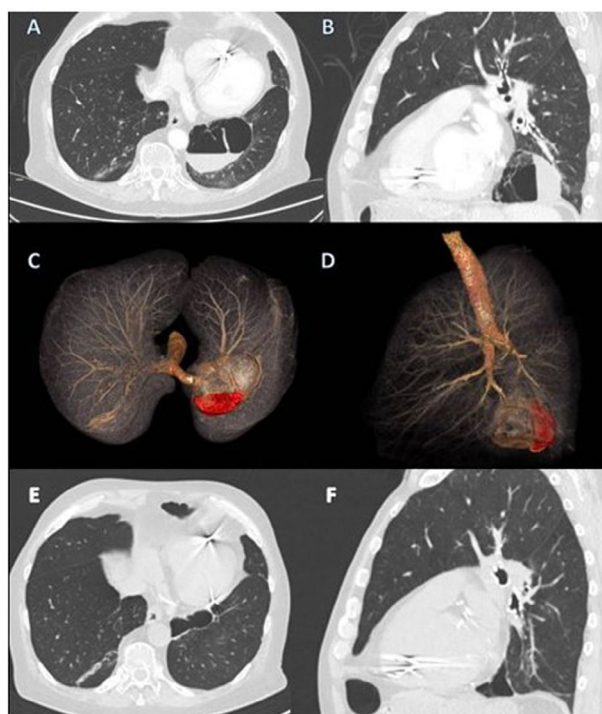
Multiplanar chest CT reconstructions with intravenous contrast in axial (A) and sagittal (B) planes where a bulla located in the medial basal segment of the LLL with hematic level is observed. 3D segmentation of the findings in axial (C) and sagittal (D) projection. In orange (C and D), the airway and bulla stand out, and bleeding is shown in red. Multiplanar CT reconstructions without intravenous contrast in axial (E) and sagittal (F) planes 5 months later. Persistence of the bulla located in the medial basal segment of LLL with smaller size and in the absence of the hematic level (E and F).
